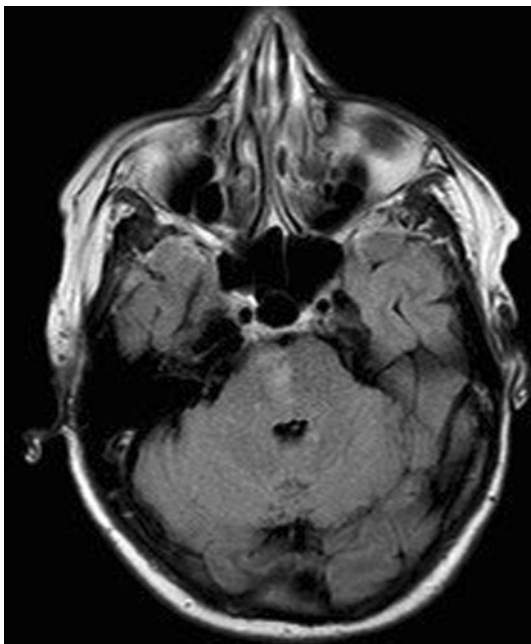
MRI of the brain depicting an acute infarct involving the paramedian region of the right pons
